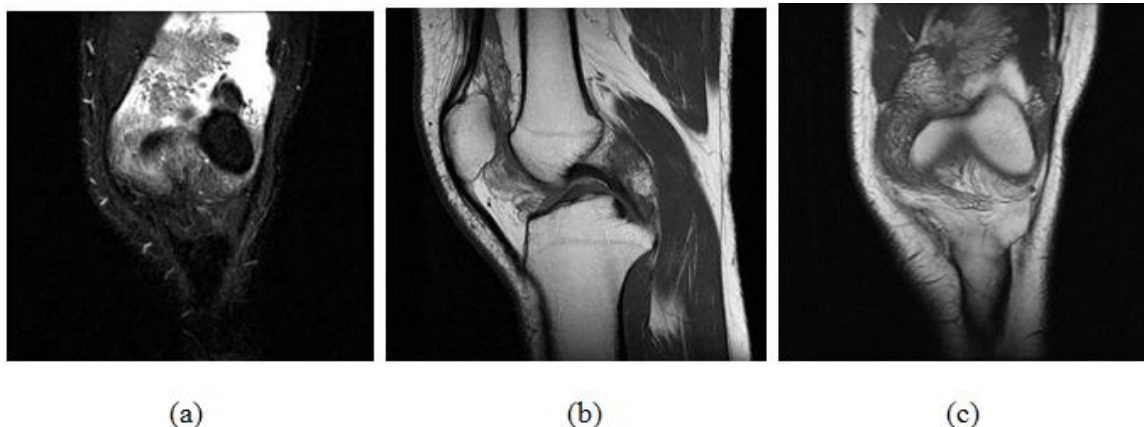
MR images on coronal Fat saturation (FS) (a), sagittal, T1-weighted image(b) T-2 coronal images depict frond-like villi projecting inwards from the synovium with signal equal to fat on all imaging sequences.
